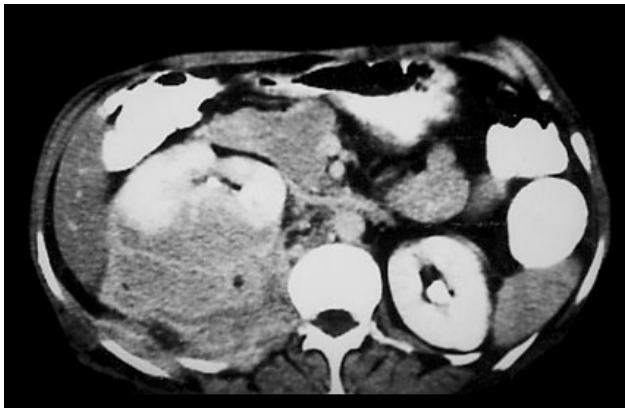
Abdominal CT scan showing a complex ill-defined mass.
